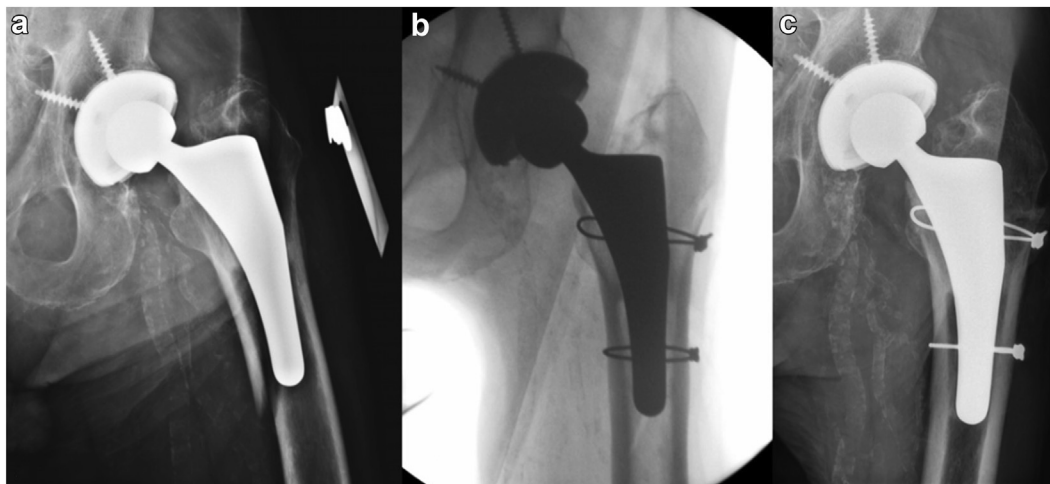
Radiographs of a periprosthetic femur fracture in an 85-year-old man after a fall demonstrate a Vancouver B2 periprosthetic fracture with subsidence of the stem (a). Intraoperative fluoroscopy was utilized to reduce the fracture with 2 cables (b). At 13 months postoperatively, the patient was doing well, with no complaints of pain in the hip (c).
